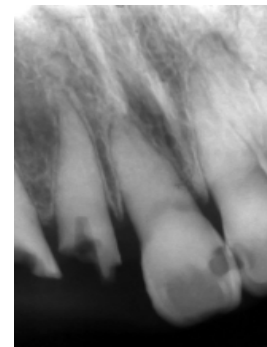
Radiograph after dental root and dental pulp treatment at 30 years of age. The dental pulp is invisible in 21.
